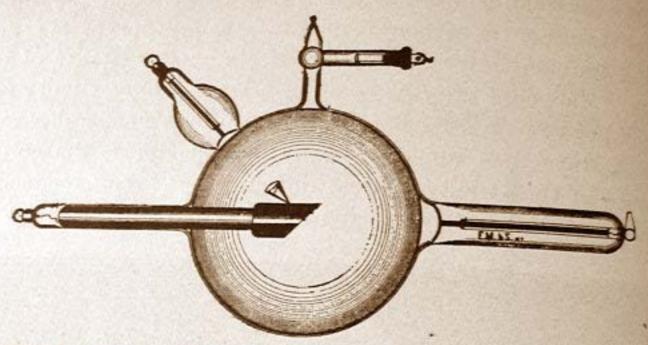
Latest Type X-Ray Tube for Either Direct or Alternating Currents.
